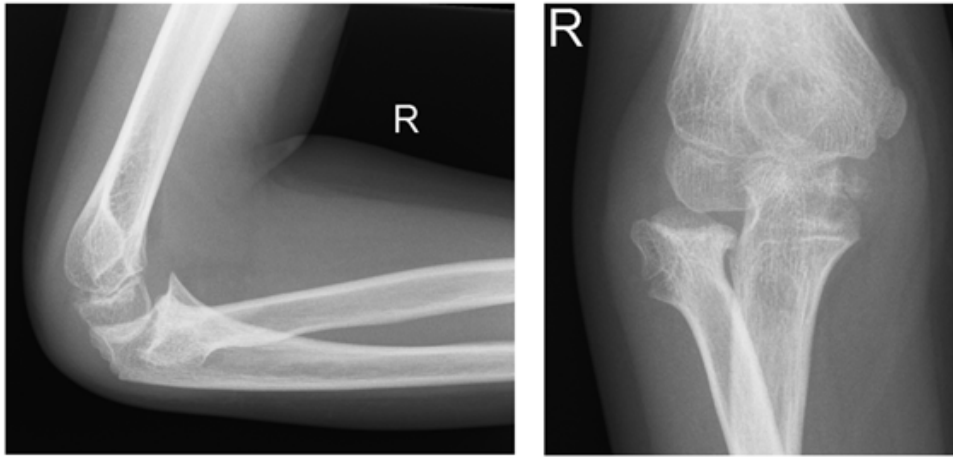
X-rays of the elbow joint at the age of almost 10 years. The proximal radius is clumped. The epiphysis is tilted laterally by 90 degrees and still has a concavity.
